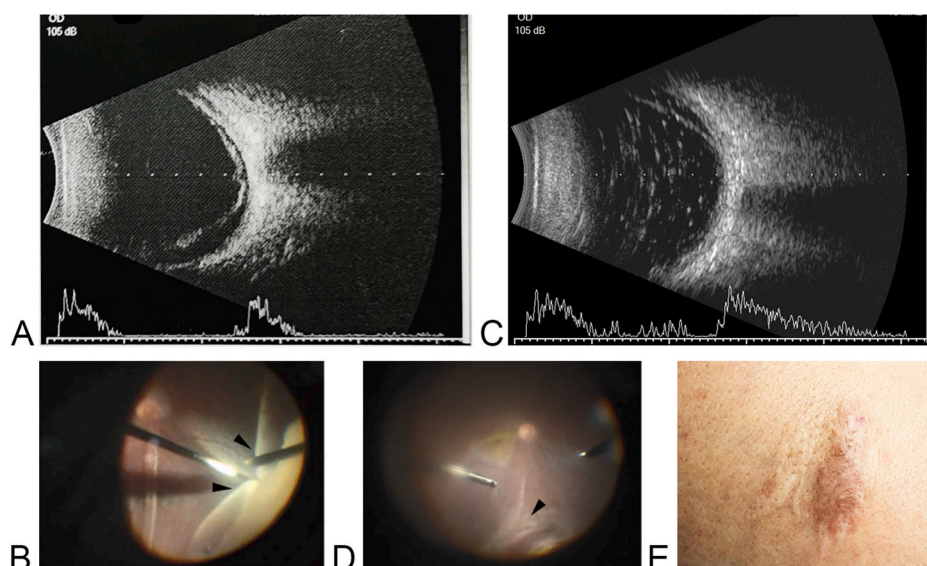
The B scan ultrasound image (2A) was performed 2 day before pars plana vitrectomy (PPV). Ocular fundus showed tractional retinal detachment during the PPV (42 days after injury). (2B, black arrows) The B scan ultrasound image (2C) showed re-detachment of retina. It was deteriorated to severe retinal cicatricial contraction 7 days after the silicone oil removal (about 6 months after injury) (2D, black arrow), and the keloid (2E) was observed on the skin wound of the thigh simultaneously.
